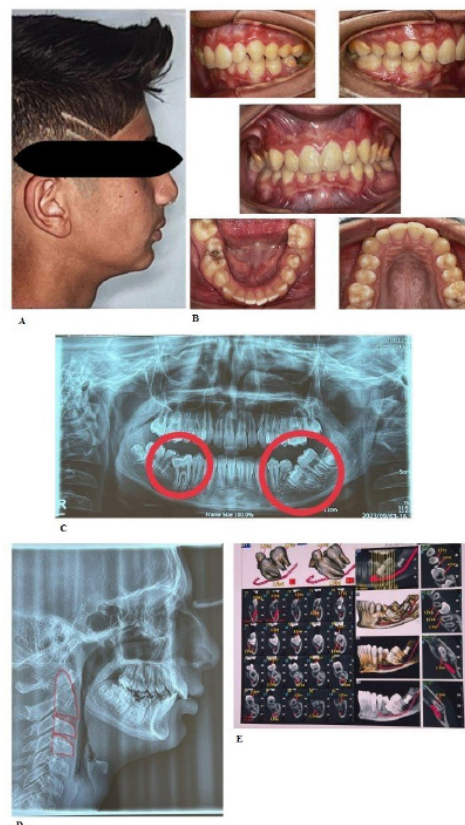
12-year-old male patient with class II malocclusion, complete transposition of lower right second premolar and permanent first molar, and vertical palisading of the permanent left first and second molars. (A: Pretreatment profile view, B: Pretreatment intraoral photographs, C: Pretreatment panoramic radiograph, D: Pretreatment cephalometric radiograph, E: Pretreatment cone-beam computed tomography).
